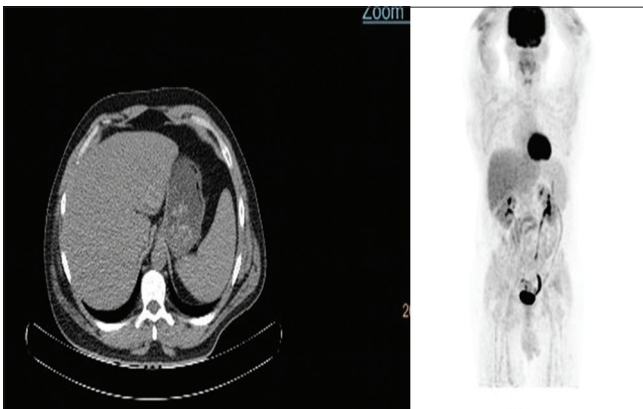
Representative example of non-steatotic patient. Maximal intensity projection and axial computed tomography (CT) image for a 42-year-old male patient addressed for interim positron emission tomography (PET)/CT of HL scored DS 1. Body mass index (BMI) was mildly increasing throughout follow-up. BMI was 36.2 and 37 kg/m² during baseline and interim PET/CT examinations, respectively.
